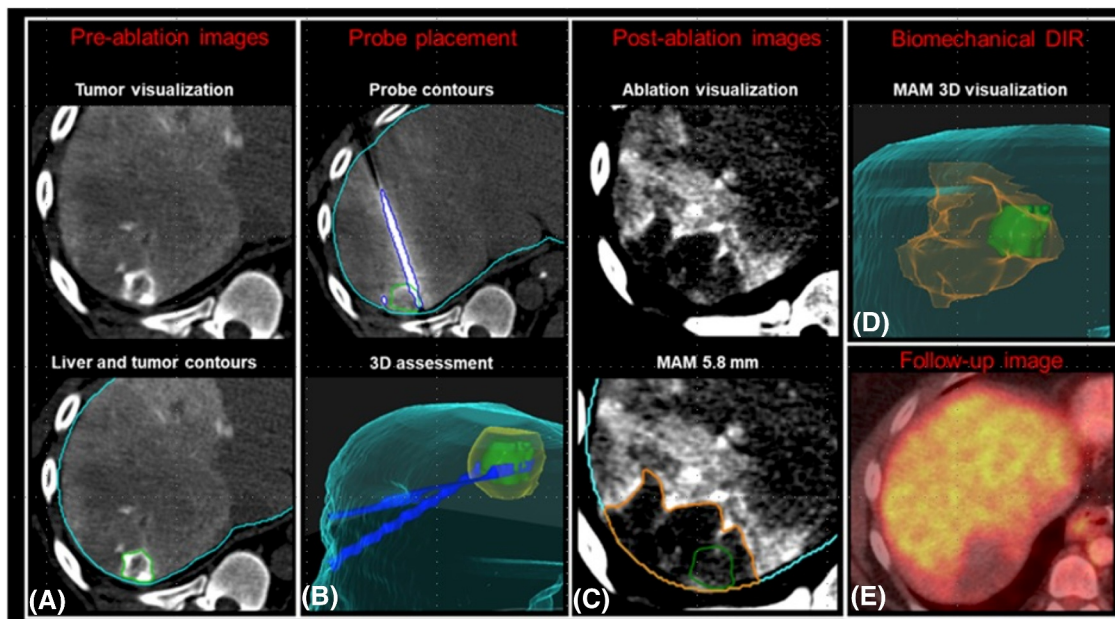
A patient aged 45 years with a solitary CRC liver metastasis. (A) An intraprocedural preablation CT during hepatic arteriography imaging with artificial intelligence-based autosegmentation of the liver (blue) and the tumor (green) revealed a 2.0-cm CLM on segment 7. (B) *Top*: Microwave applicators (blue) within the target tumor shown on a noncontrast CT image. *Bottom*: A 3D reconstruction of the CT images showed the microwave applicators (blue) within the tumor (green) with the preplanned, expanded ablation coverage of 5 mm (yellow). (C) *Top*: Intraprocedural postablation showed the ablation zone; the tumor was no longer visualized because it was encompassed by the ablation zone. *Bottom*: Artificial intelligence-based segmentation was used to visualize the ablation zone and tumor; the tumor was projected from the preablation image by image co-registration using biomechanical deformable registration. (D) A 3D representation showed the ablation zone covering the entire tumor with the intended minimal ablative margin (6.4 mm). (E) A fused positron emission tomography–CT image showed that the tumor had a complete response to the ablation at 2 months. 3D indicates three-dimensional; CLM, colorectal liver metastasis; CRC, colorectal carcinoma; CT, computed tomography; DIR, deformable image registration; MAM, minimum ablative margin.
